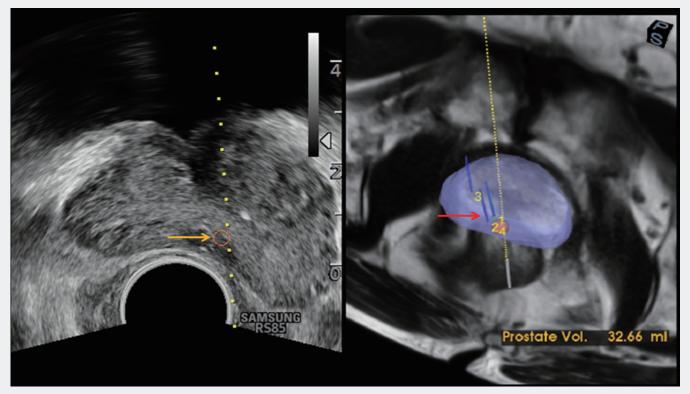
The software for prostate image fusion allows precise targeting of the prostate biopsies based on 3D model. Target lesion marked as a red sphere in MRI and in conventional B-mode (yellow arrow). The already done biopsies are reported in the prostate model (red arrow).
